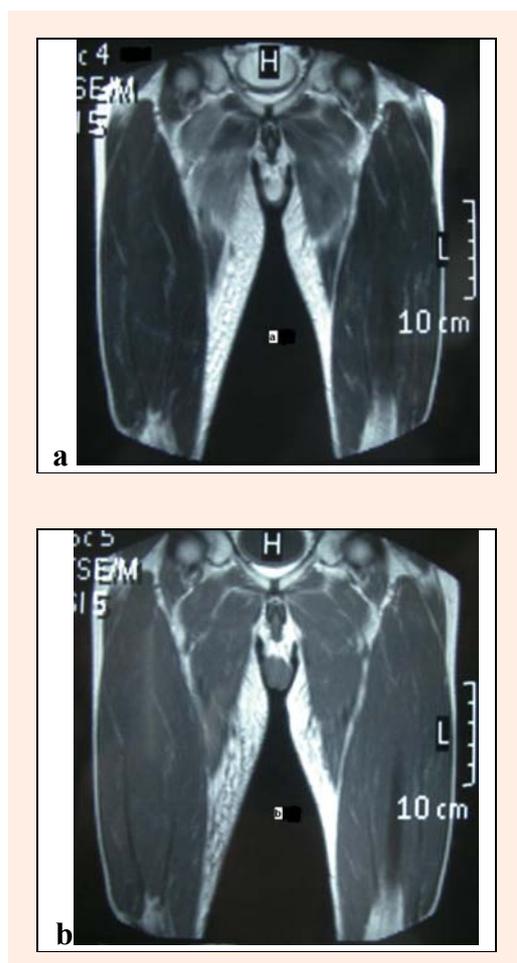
Coronal T2-weighted image (a) shows high signal intensity in the bilateral adductor magnus with slight swelling and subcutaneous edema at the medial thigh. Coronal T1-weighted image (b) shows an iso-signal intensity compared with other muscles.
